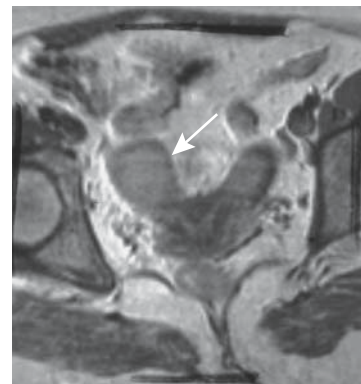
Endometrial carcinoma in a bicornuate uterus. A transverse oblique MR image identifies an intrauterine tumor (arrow). (Source: Burgener FA, Meyers SP, Tan RK, Zaunbauer W. *Differential Diagnosis in Magnetic Resonance Imaging*. Stuttgart: Thieme, 2002, with permission.)
